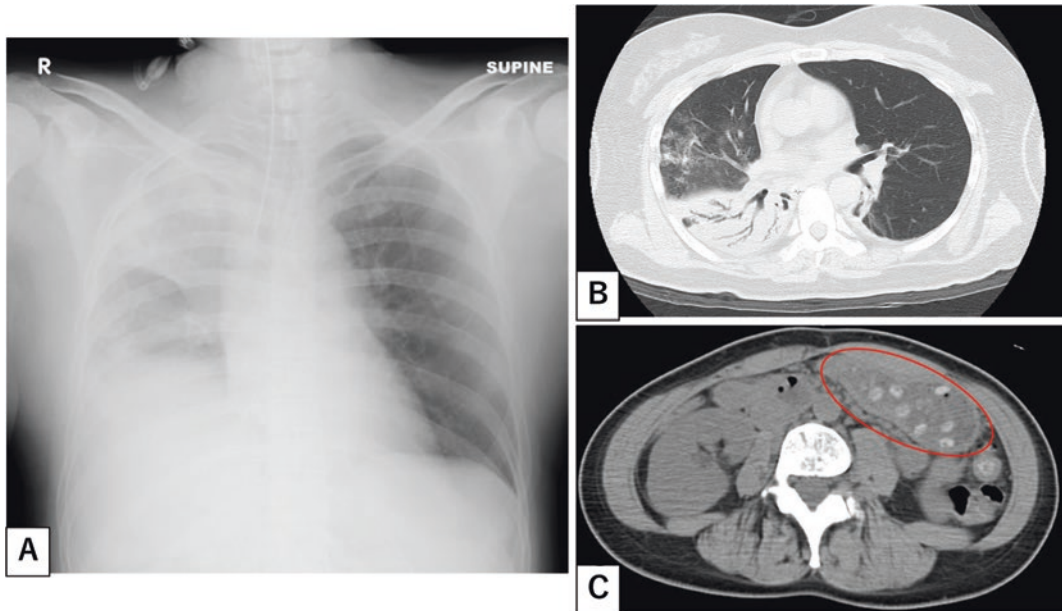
Thirty-five-year-old female with aspiration pneumonitis of the right lung. (a, b) Right upper lobe infiltrates due to aspiration (a, chest X-ray; b, CT). (c) Radiopaque tablets identified in the stomach (CT)
